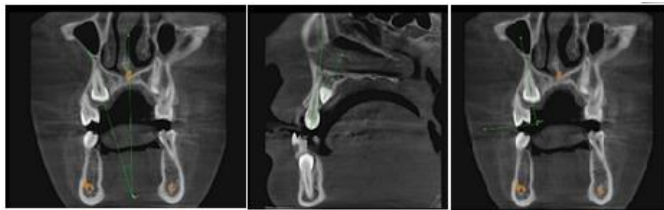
d1 and d2 measured in CBCT
